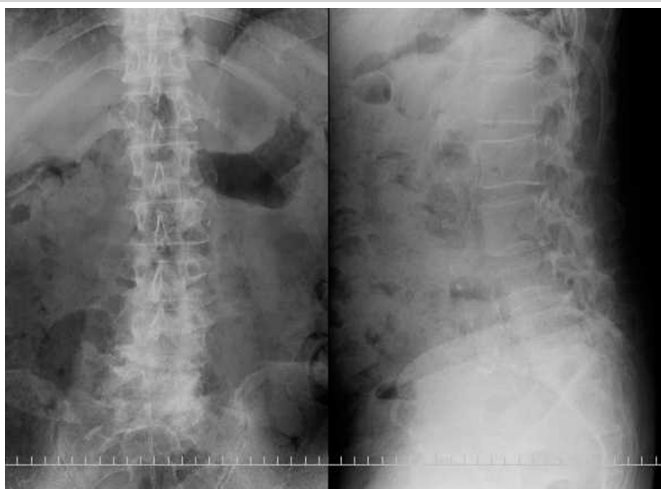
Pre-operative lumbar lateral X-ray images (a. neutral frontal view, b. neutral lateral view, c. backward bending lateral view, and d. forward bending lateral view). The images showed a decrease in the intervertebral space of L4/5 and L5/S. On the other side, in the intervertebral space of L3/4, maintaining the intervertebral disc heights, and instability was unclear.
